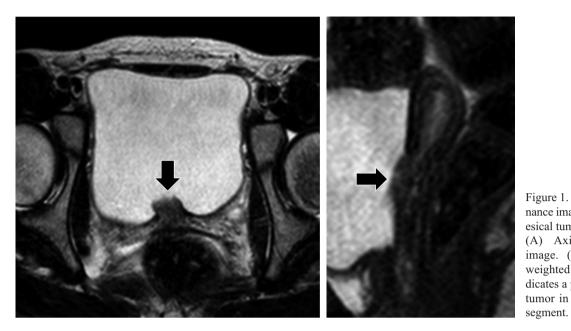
Magnetic resonance imaging of the intravesical tumor.
